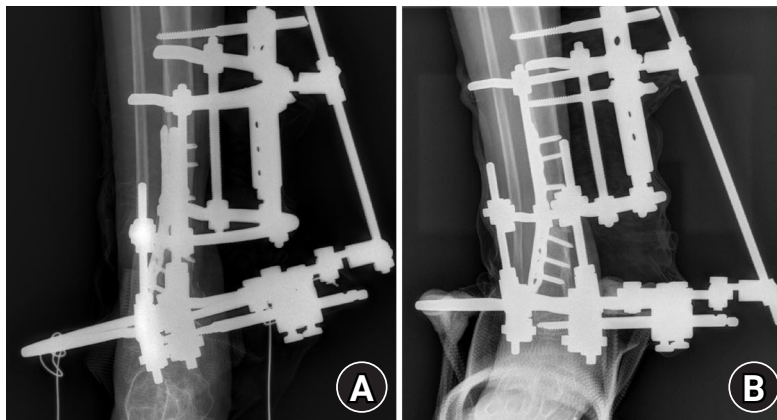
Ilizarov fixation for correction/overcorrection. (A) Anteroposterior radiograph obtained after application of an Ilizarov external fixator for deformity correction, intentional overcorrection, and alignment management. (B) Lateral radiograph obtained after application of an Ilizarov external fixator for deformity correction, intentional overcorrection, and alignment management.
